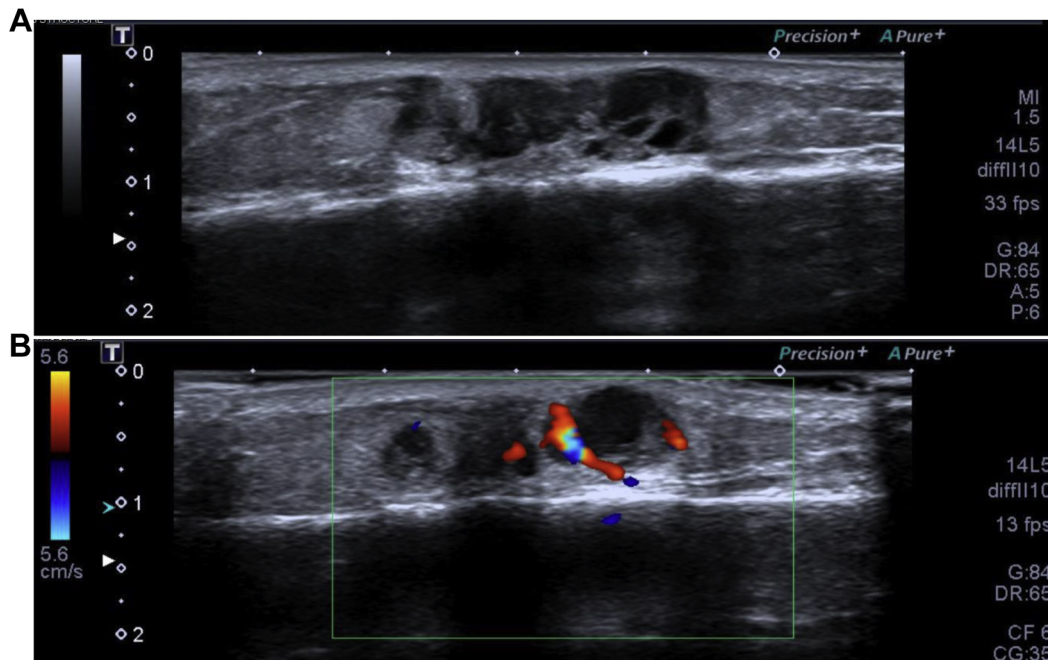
Ultrasound evaluation of the eccrine spiradenoma on the right leg showing a multilobulated hypoechoic lesion in the subcutaneous layer abutting the deep dermis (A) with internal vascularity on color Doppler ultrasound (B).
